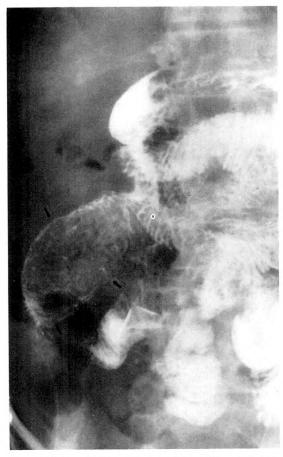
Case I. Barium coats a large filling defect in the ileum on the 30 minute small bowel roentgenogram.
